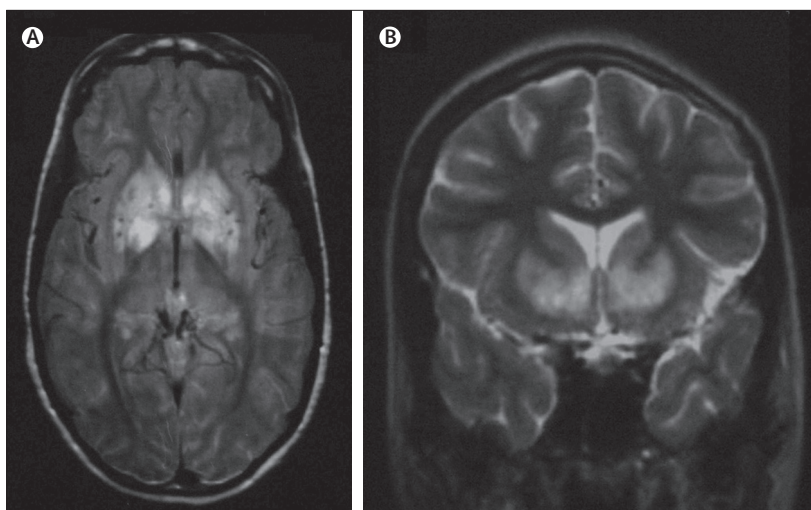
FLAIR and T2-weighted MRI of acute disseminated encephalomyelitis
